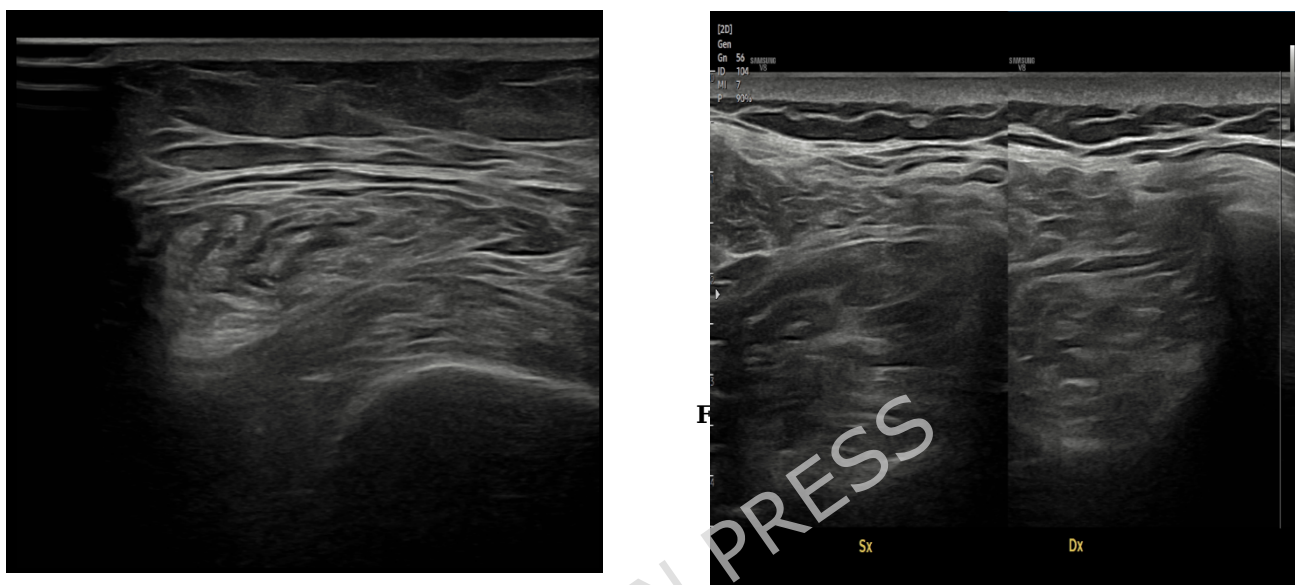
Ultrasound transverse images of typical sarcopenic patient.
